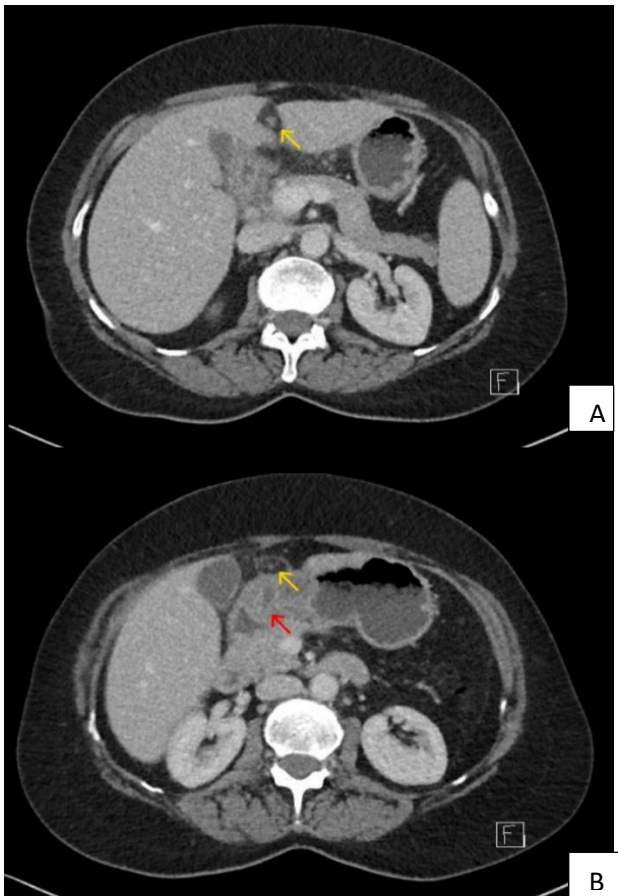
(A and B): CT abdomen pelvis with portal venous contrast; axial slices demonstrating the recanalised umbilical vein with thrombus (yellow arrow), and thickening of the gastrum antrum (red arrow).
